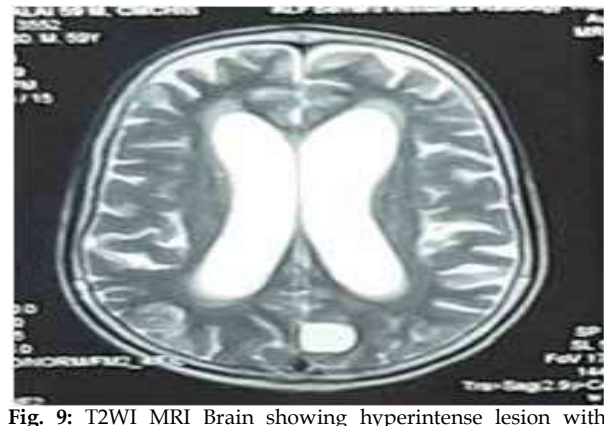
T2WI MRI Brain showing hyperintense lesion with central scolex with hydrocephalus
